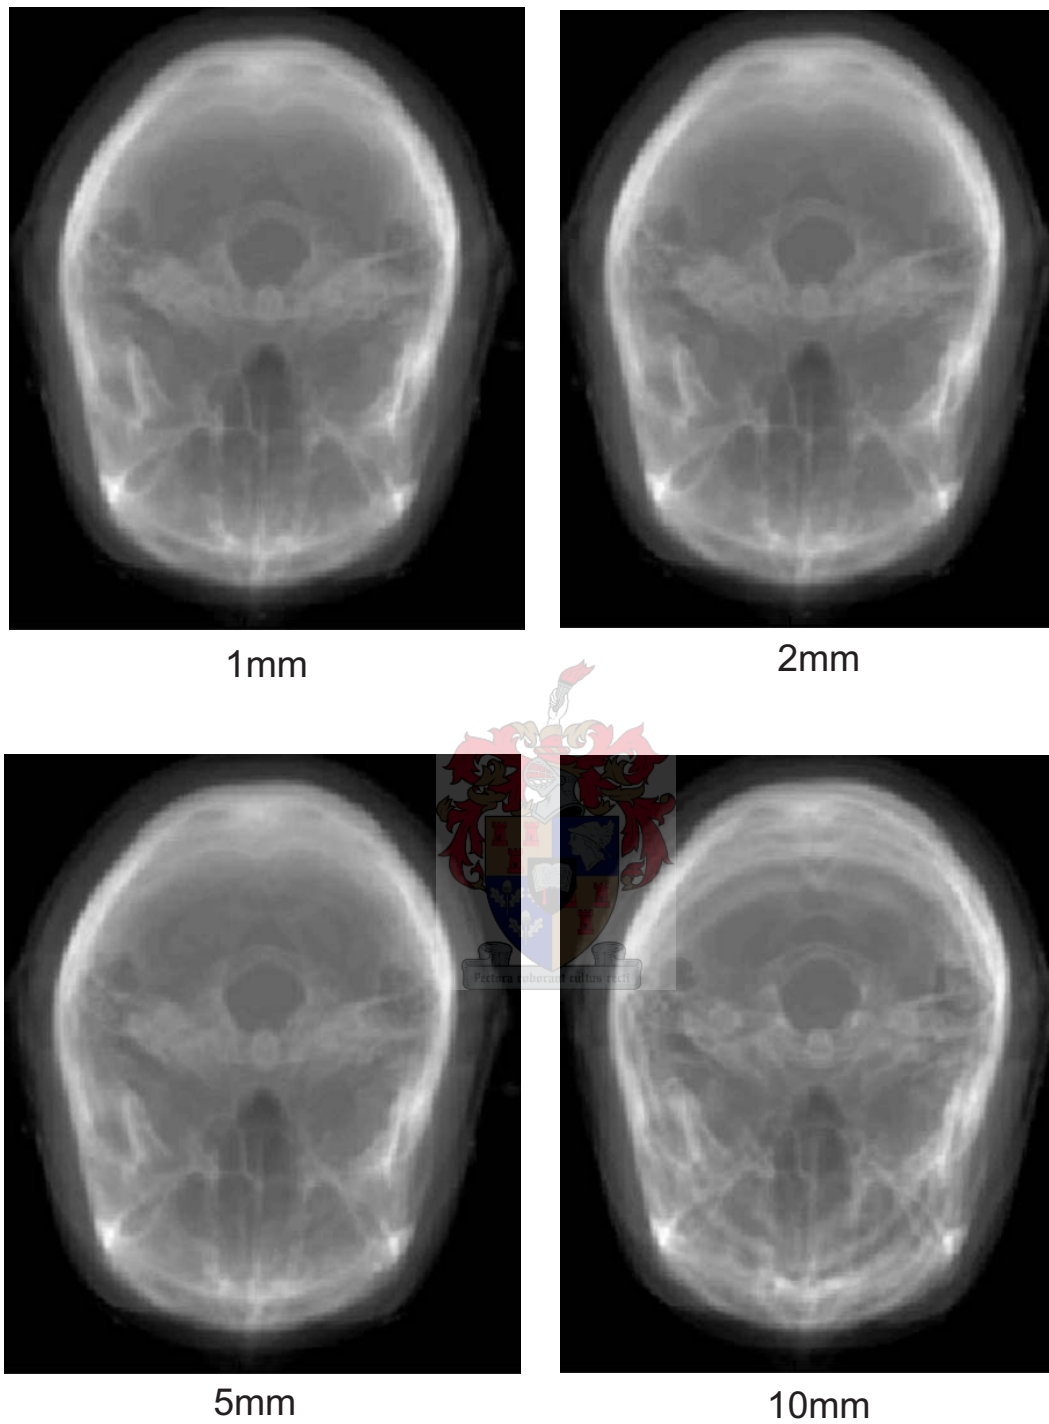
DRR generated from CT data with 1mm, 2mm, 5mm and 10mm slices. DRRs generated with a view perpendicular to the CT image slices
